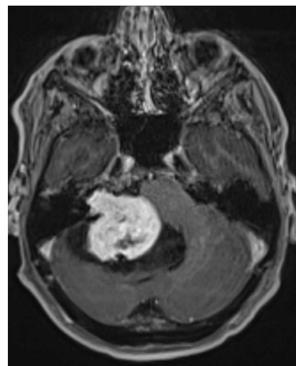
MRI demonstrating right cerebellopontine angle mass, with significant involvement of the auditory canal and compression of the brain stem.
